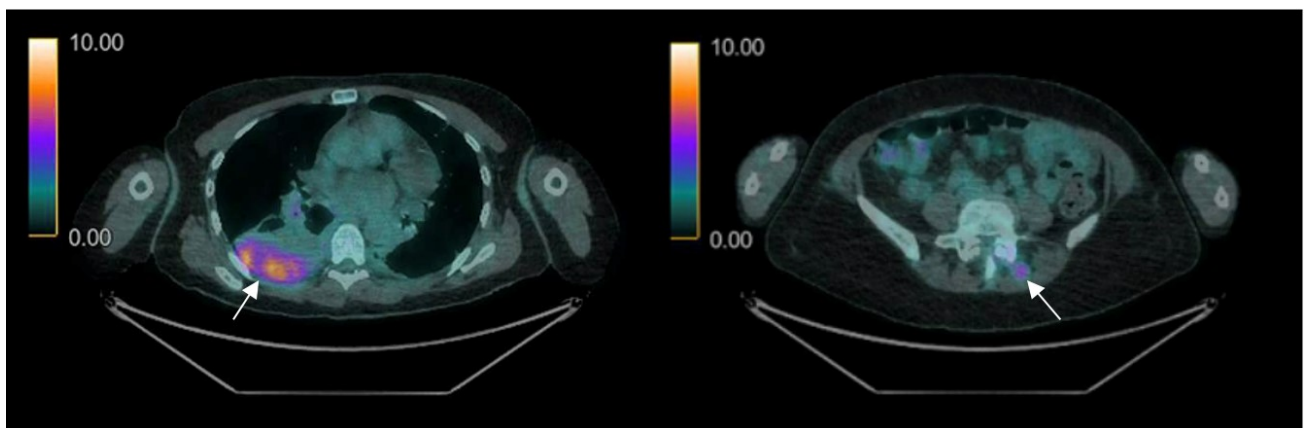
Both images from FDG PET-CT scan. Left-hand side image: arrow marking area of patchy increased pleural avidity concerning for right-sided empyema. Right-hand side image: arrow locating area of increased avidity on the left L4/L5 facet joint. FDG PET-CT, fluorodeoxyglucose positron emission computed tomography.
